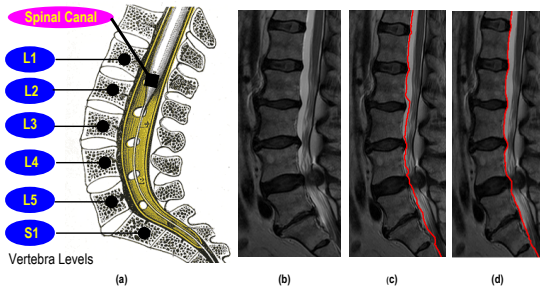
(a) Lumbar spine anatomy [14], (b) a T2-weighted sagittal image, (c) an output boundary overlaid on an input image by the intensity-based method, and (d) an output boundary overlaid on an input image by the gradient-based method.
